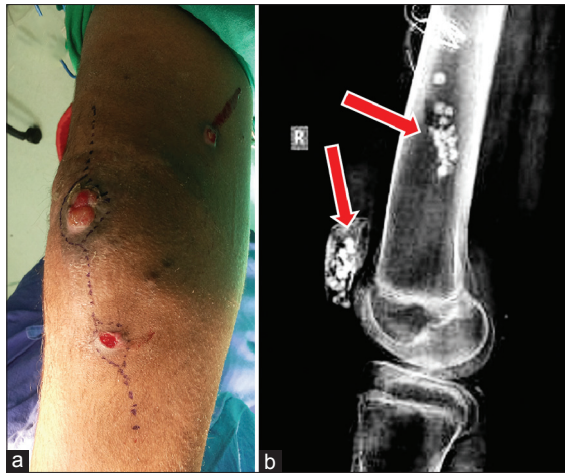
(Case A2) (a) Clinical photograph showing multiple discharging sinuses around the knee. (b) postoperative radiograph of the knee joint lateral view showing bio-degradable cement beads (arrows)
